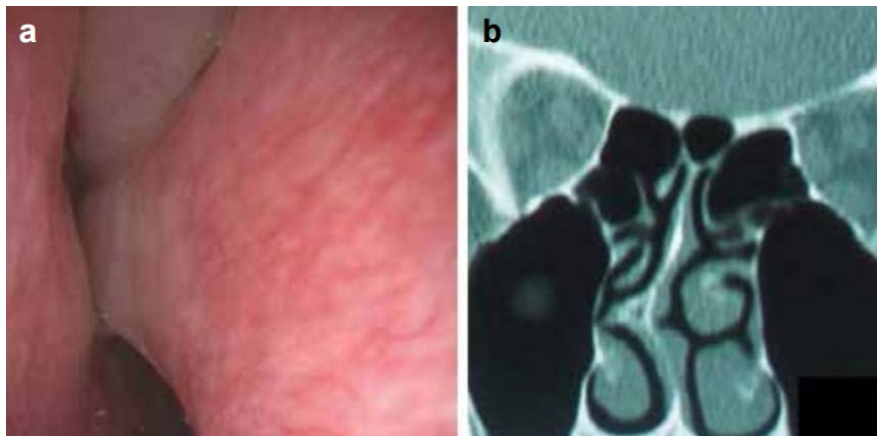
Right side type 5. a: Spur with close contact with the lateral nasal wall. b: Coronal CT with spur deep in the nose (only orbital apex is visible)
